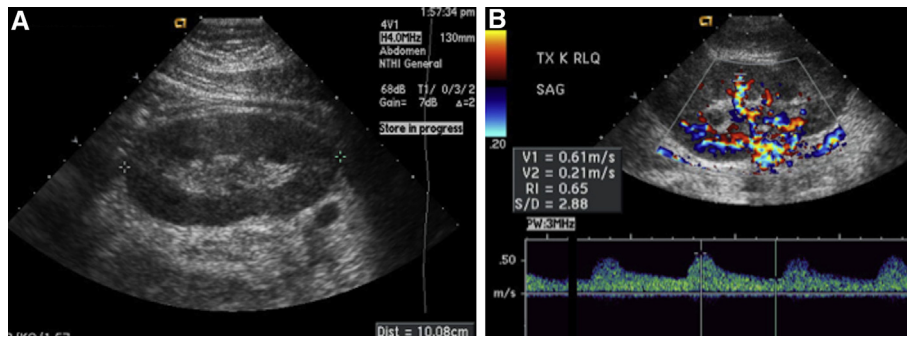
Normal ultrasound (US) findings of a transplanted kidney. (A) Grey-scale US, showing normal size and echogenicity of the kidney. (B) Colour-Doppler US, showing a resistive index within normal limits in the interlobar arteries.
